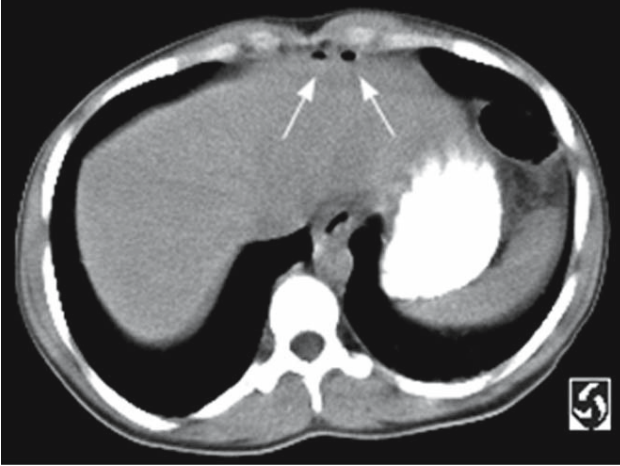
CT: two pockets of extraluminal gas in the epigastric region (*arrows*)
